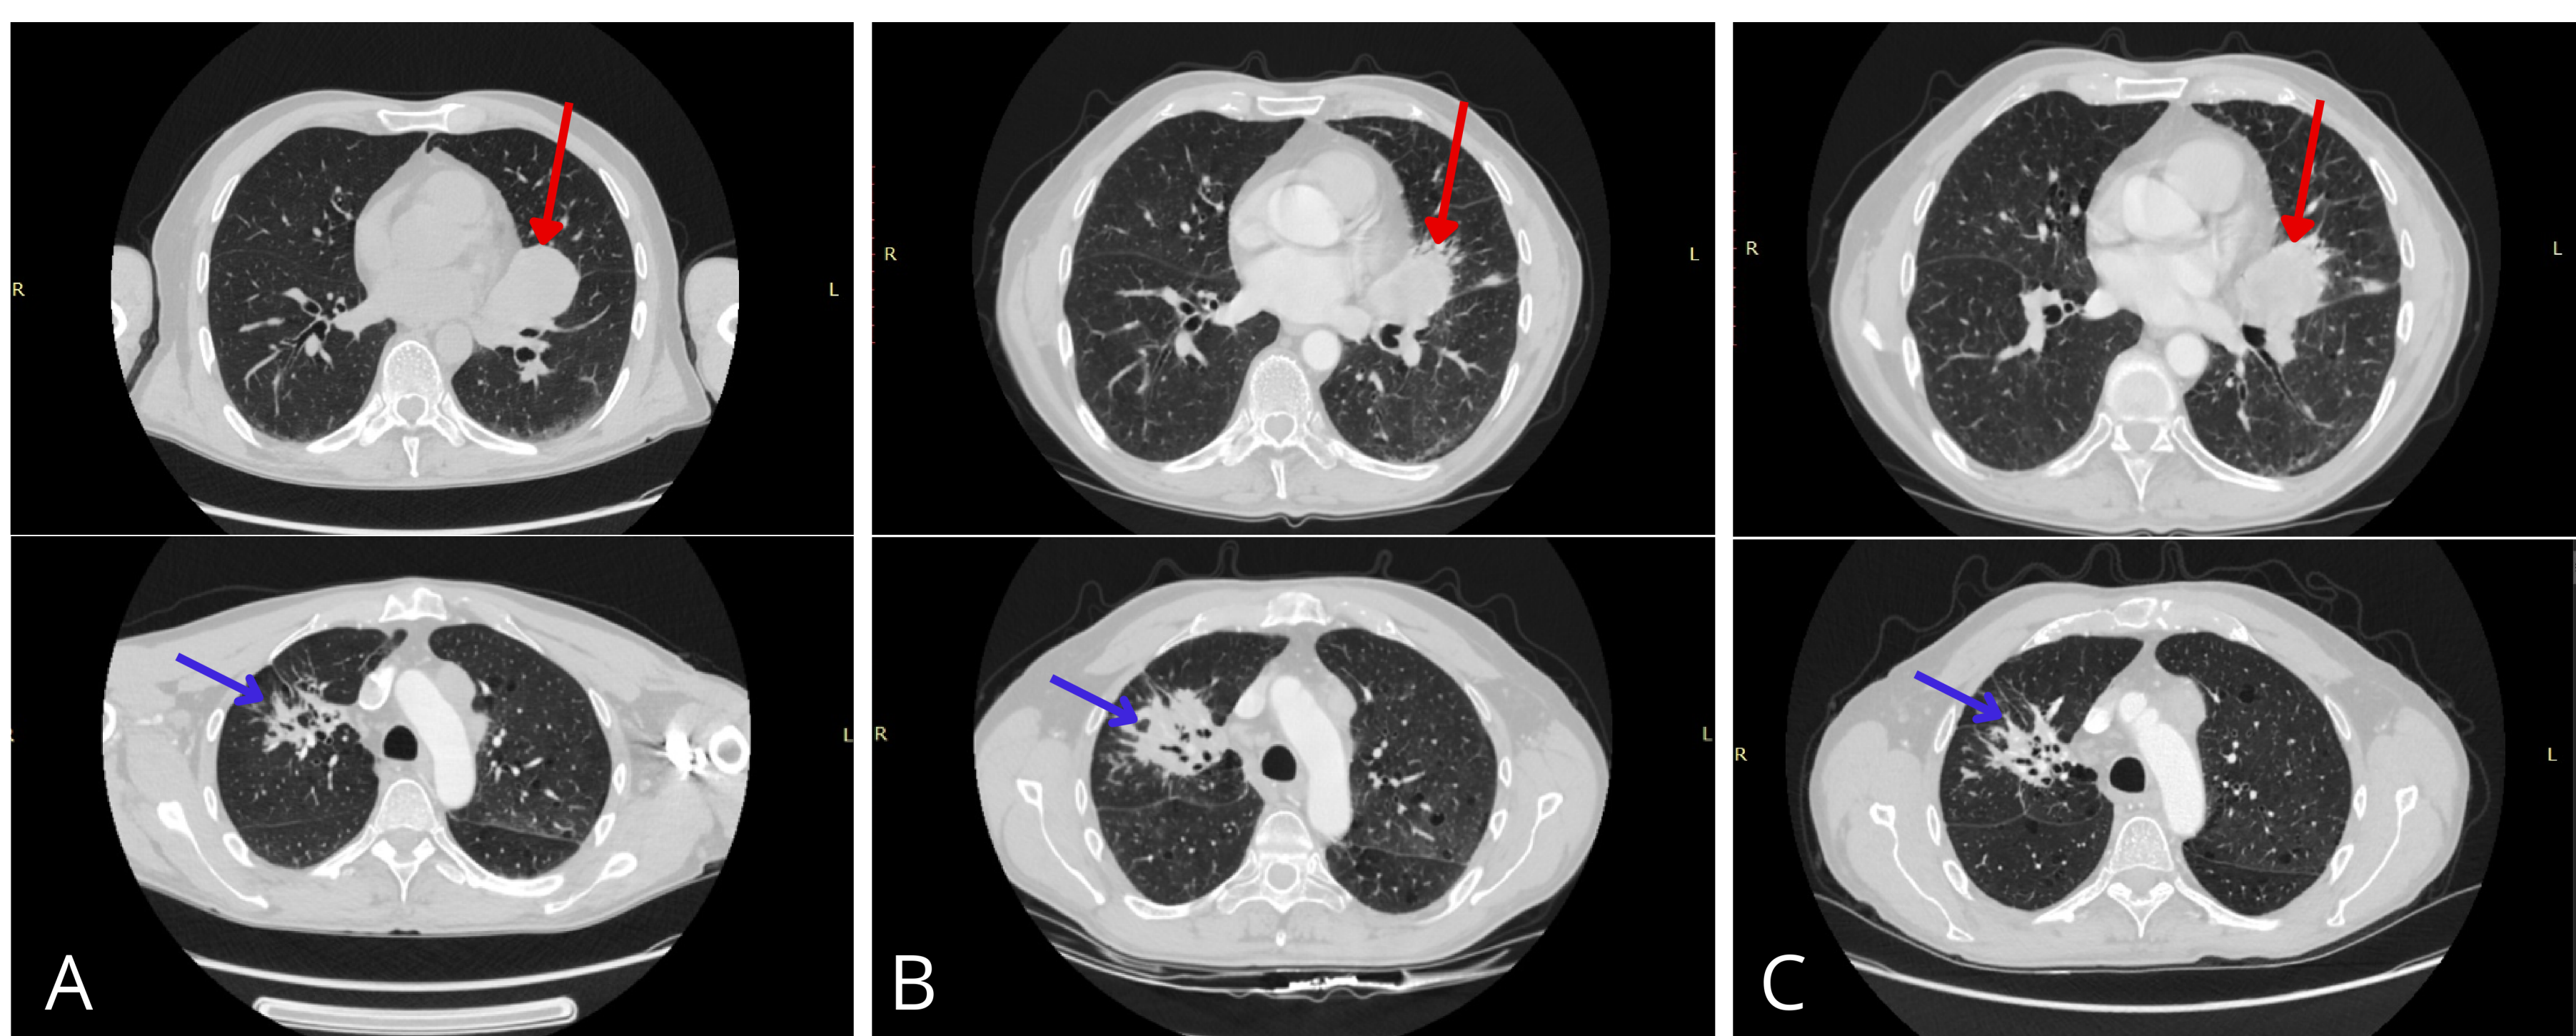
CT scans of patient with lung adenocarcinoma during immunotherapy (pembrolizumab). (A) CT from 20/01/23 (before treatment) Target lesion (red arrows) and lesion described as post-inflammatory (blue arrows) in the upper right lobe (stable for a year). (B) CT from 02/02/24 Regression of target lesion. Progression of lesions in upper right lobe, described by Radiologist as progression of cancer. (C) CT from 24/04/24 during anti-TBC treatment: Stable target lesion, lesions in upper right lobe, with tendency to regress.
